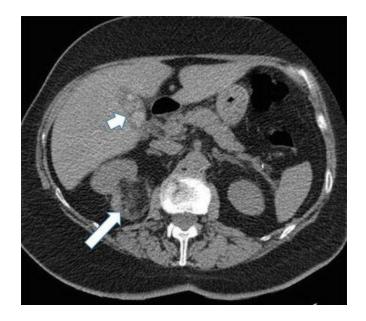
Angiomyolipoma (AML) in the posterior part of the right kidney (*long arrow*), incidentally detected on acute non-enhanced abdominal CT in a 75-year-old woman with abdominal pain. The fatty components (mean -45 HU) are characteristic for AML. The maximum diameter of the lesion was 7 cm, and due to the risk of spontaneous bleeding, the lesion was embolized. Note also faintly calcified stones in the normal-sized gallbladder (*short arrow*)
